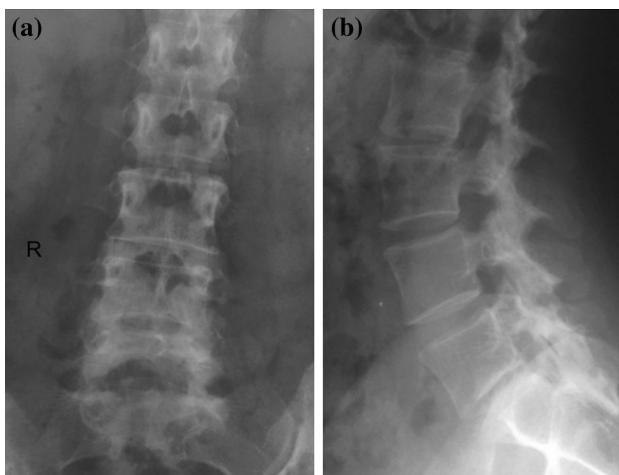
X-rays showing slight narrowing of the L5S1 disc space with increased sclerosis along the enplates (a, b)
